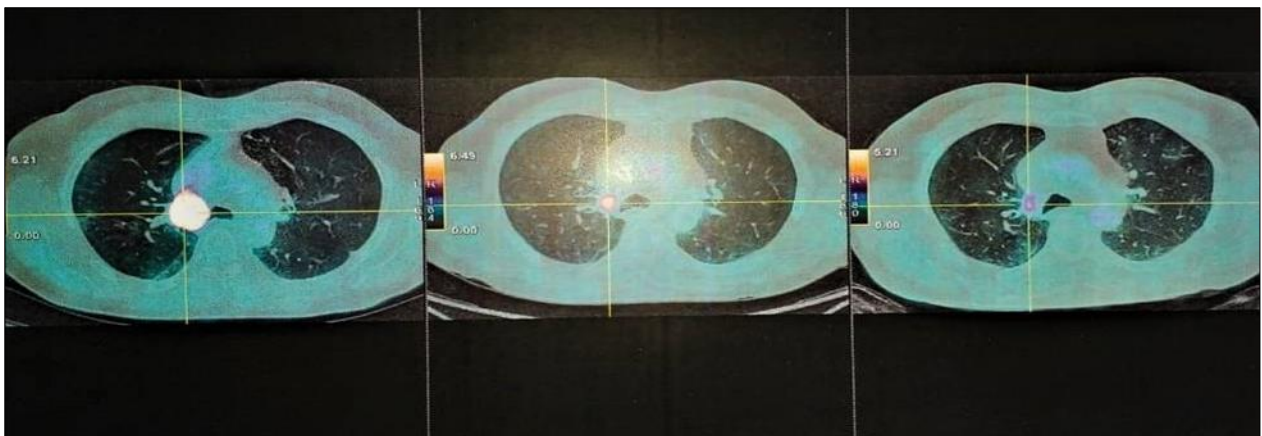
Computed tomography of the thorax demonstrating tumor process mediastino-pulm right parahilar
